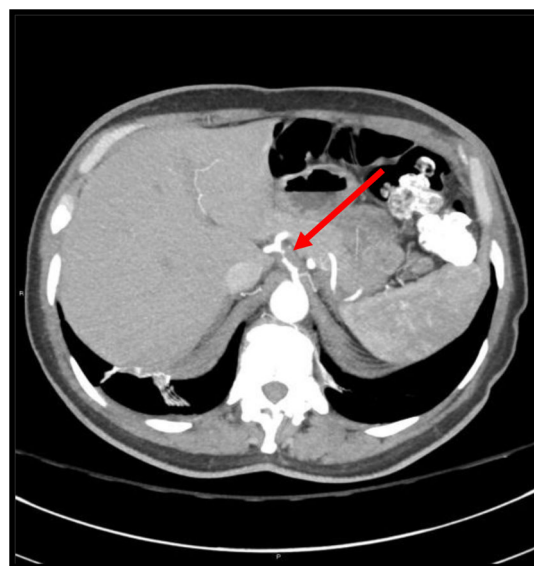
Computed tomography – chest, abdomen, and pelvis from the second admission: The celiac artery is now severely narrowed with surrounding soft tissue density, consistent with celiac artery dissection, as shown by the arrow. The soft tissue density represents infiltration of fat.
